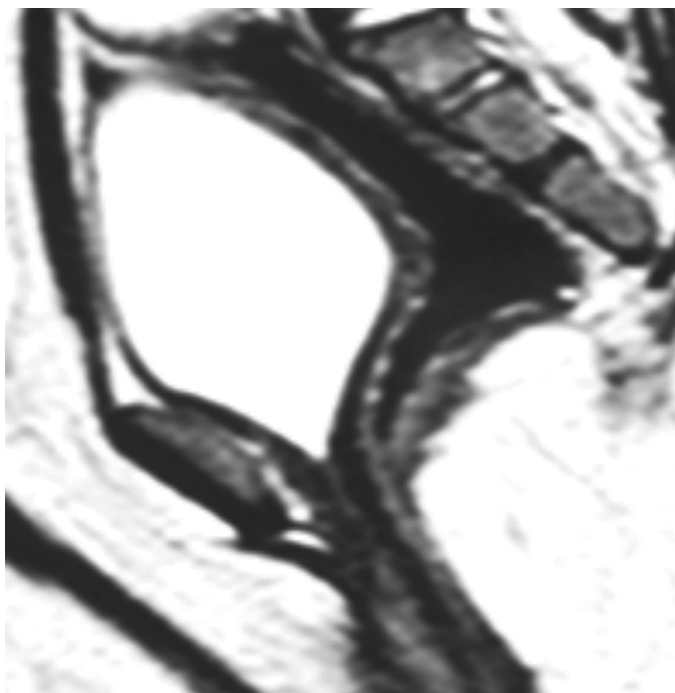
Magnetic resonance imaging pelvis showing uterovaginal agenesis and the dilated rectum
